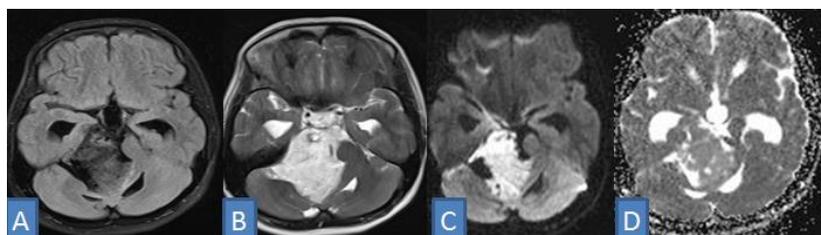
A case of epidermoid cyst in at right CP angle extending to right parapontine , prepontine ,right ambient and quadrigeminal cisterns appearing hypointense on FLAIR (A), hyperintense on T2WI (B), showing restriction on DWI (C), with low ADC values (D).
